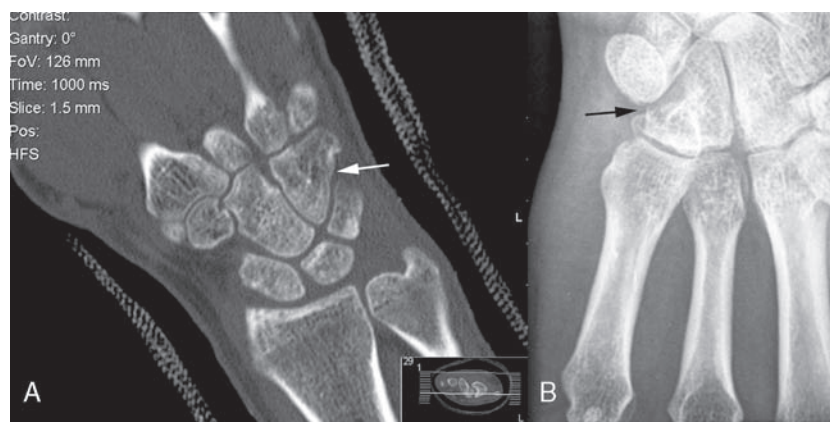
A) Follow-up CT at 8 weeks. B) Follow-up x-ray at 16 weeks.
